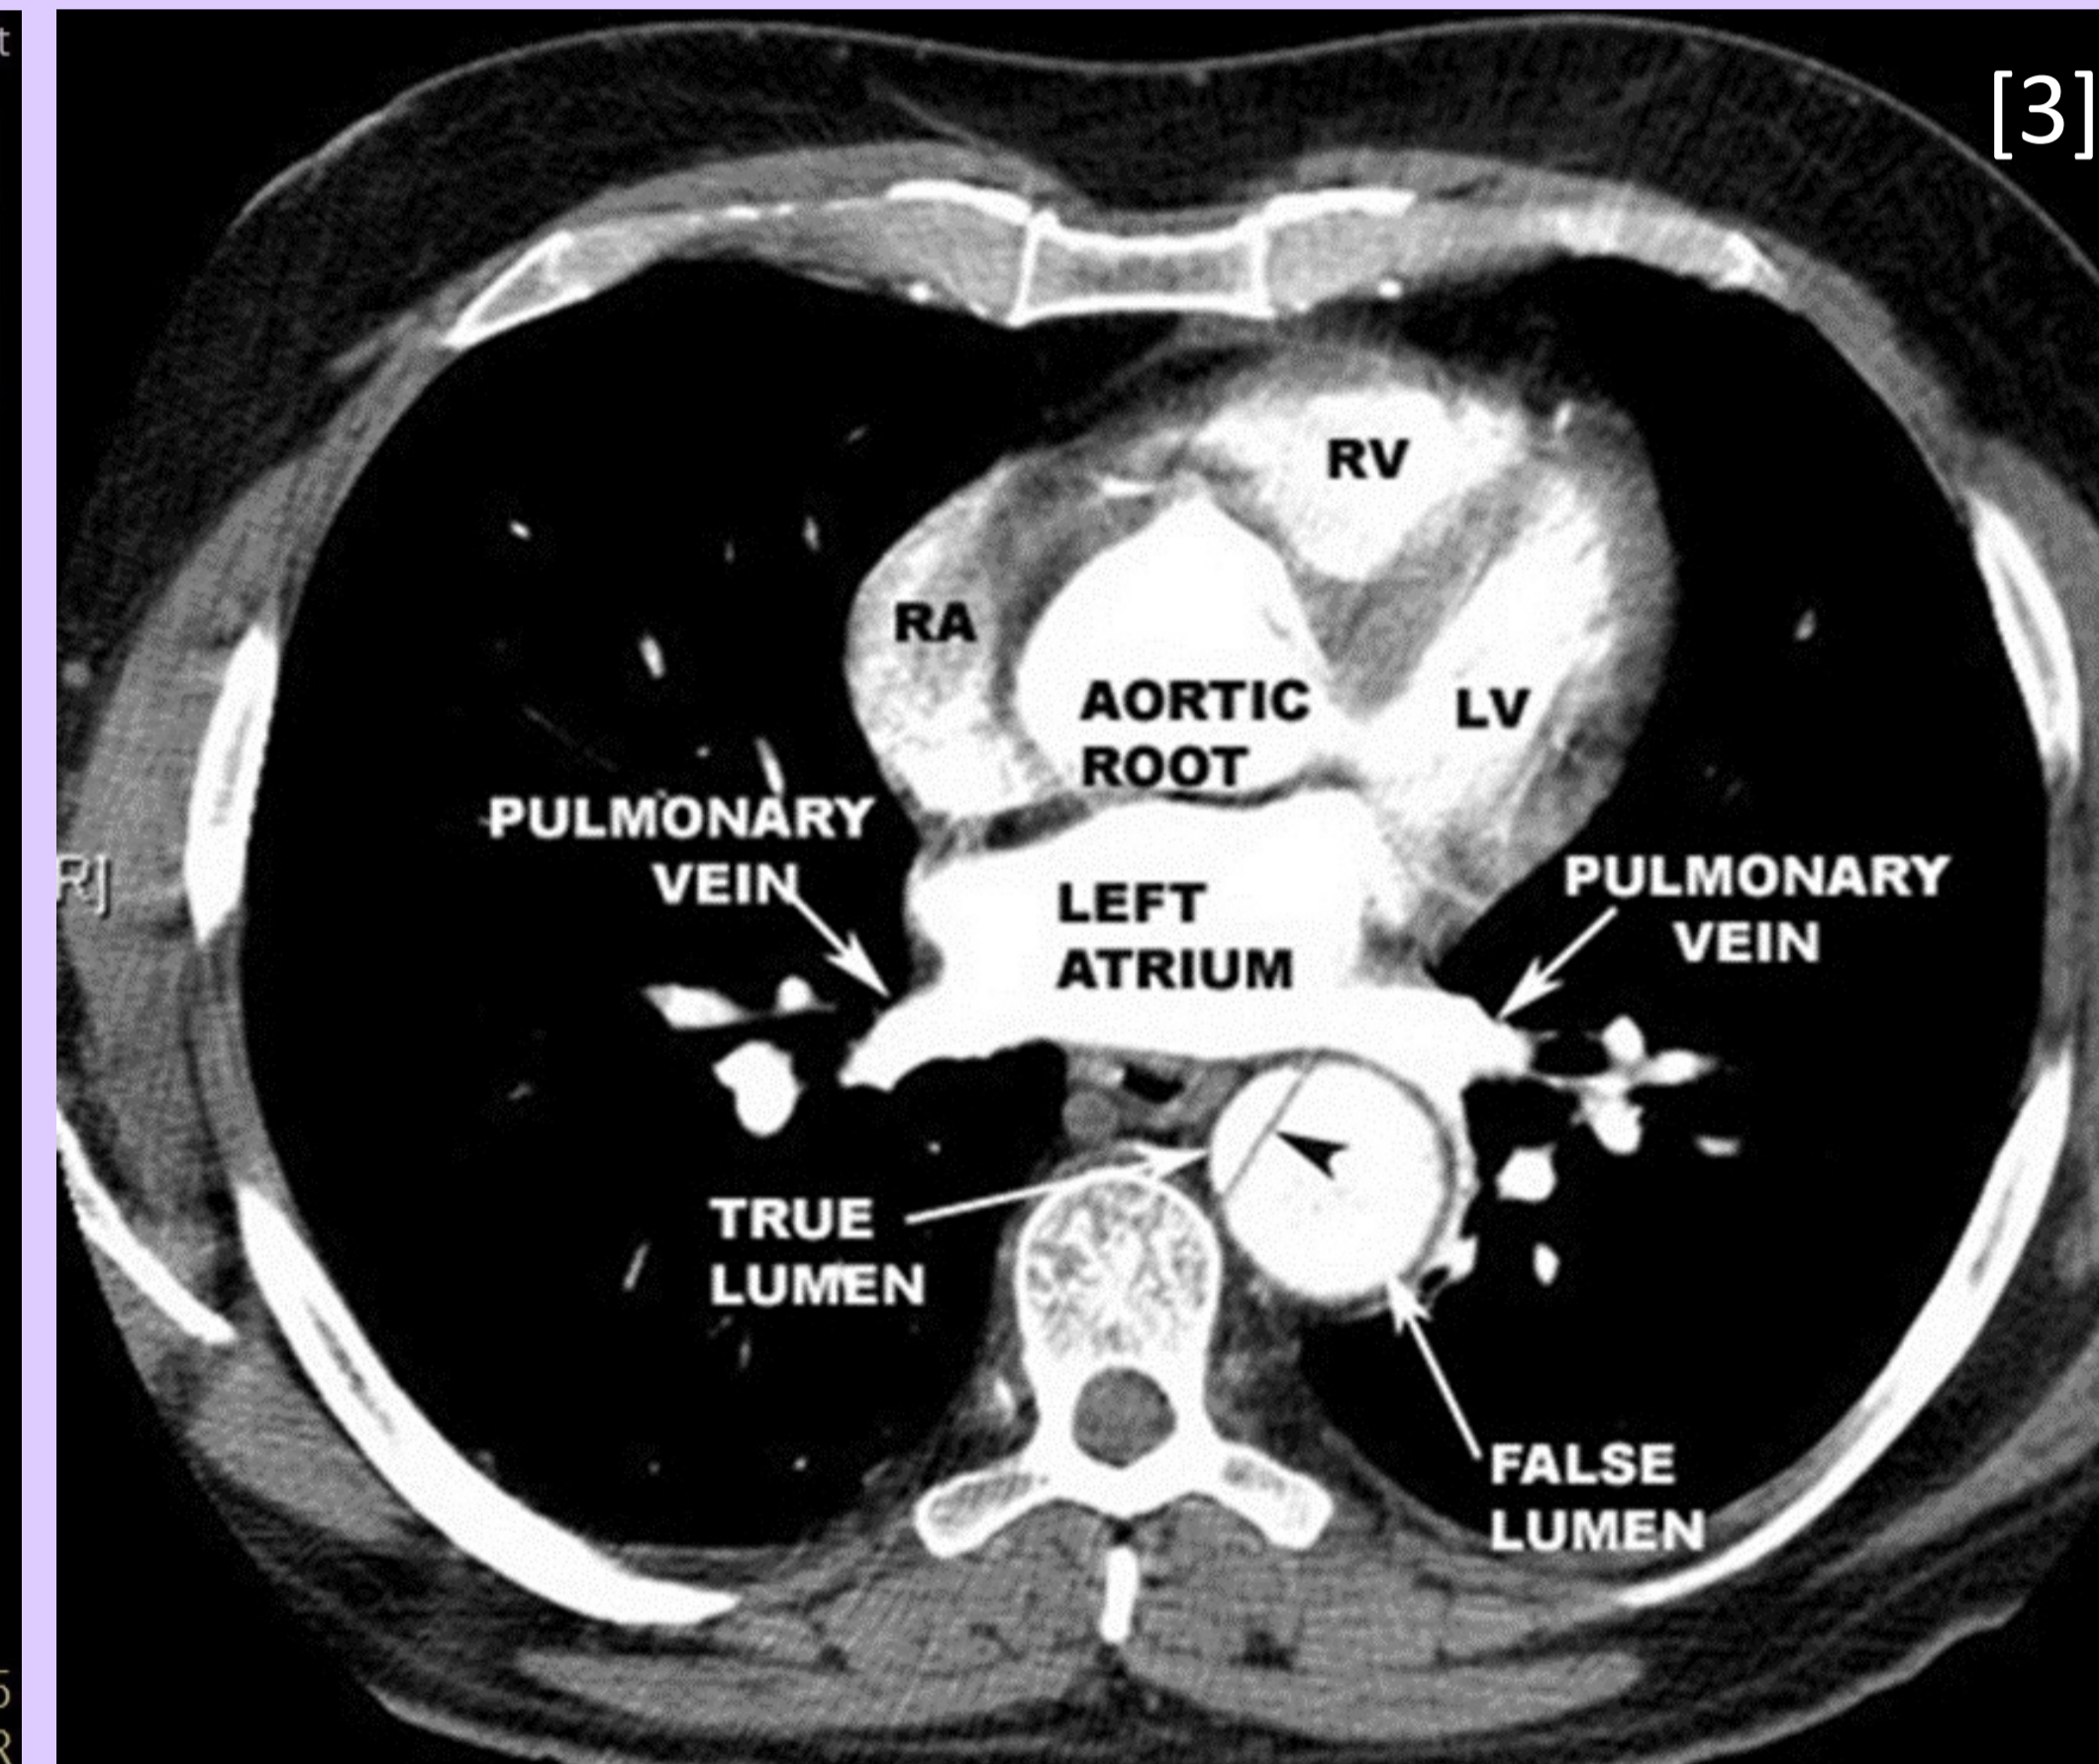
CT image of Stanford A aortic dissection
